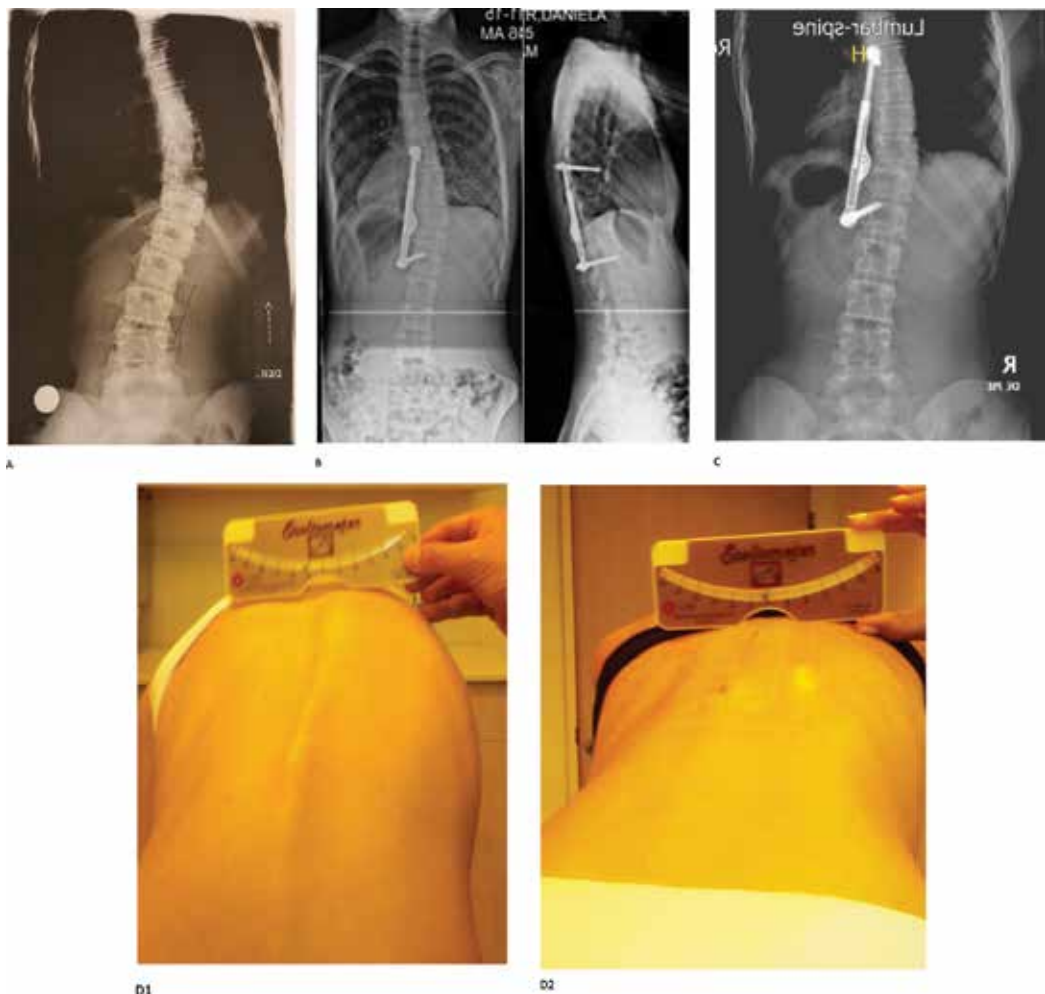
Case 2: (A) Preoperative standing AP X-ray and (B) postoperative standing AP & lateral X rays, and (C) after 9 months of exercises. The expandable rod has elongated with further curve reduction. D1: Scoliometer measurement before surgery 7. D2: Scoliometer measurement after surgery 2.
